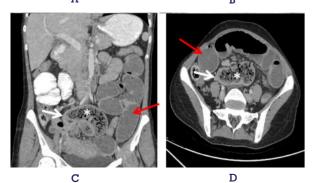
(A) & (B) USG showing dilated small bowel loops with transition point at distal ileum with tubercular thickening of distal ileum. CT coronal (C) and axial (D) planes showing dilated small bowel loops (red arrows) with small bowel faeces sign (asterix) - s/o small bowel obstruction. Transition point is noted at distal ileum (white arrow).
